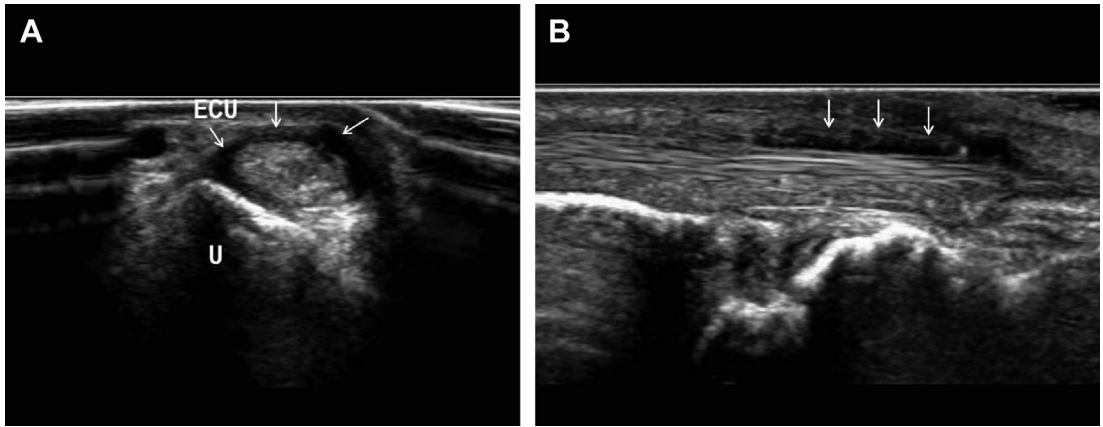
Ultrasonography of the right wrist ECU tenosynovitis. Longitudinal (A) and axial (B) views showed anechoic fluid in the tendon sheath (*white arrows*). U, ulna.
